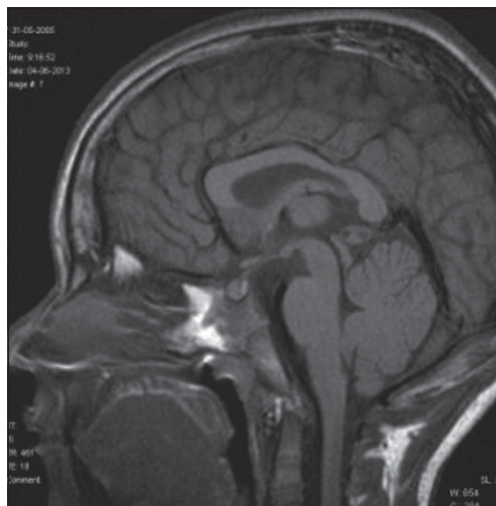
Brain magnetic resonance imaging (MRI). Brain and sellar resonance reports a small pineal cyst that is considered a finding.
